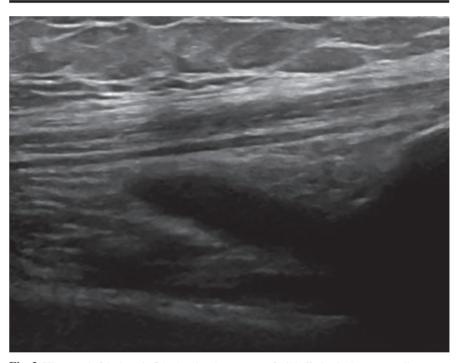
Ultrasound of the knee in OA, showing the presence of mild effusion in the suprapatellar recess.
